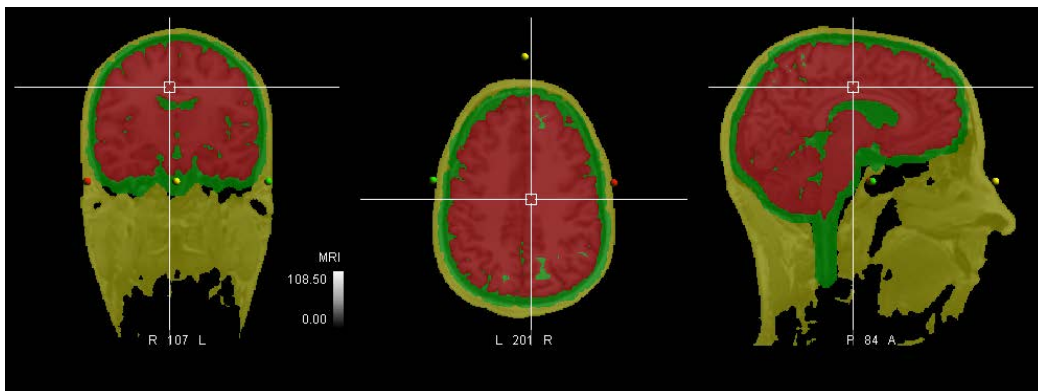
MRI segmentation of scalp, skull and brain.
